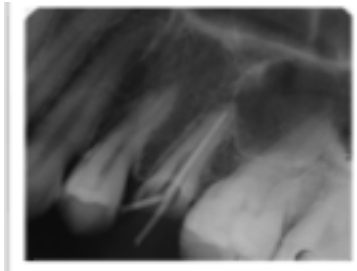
Filling trial radiograph.
